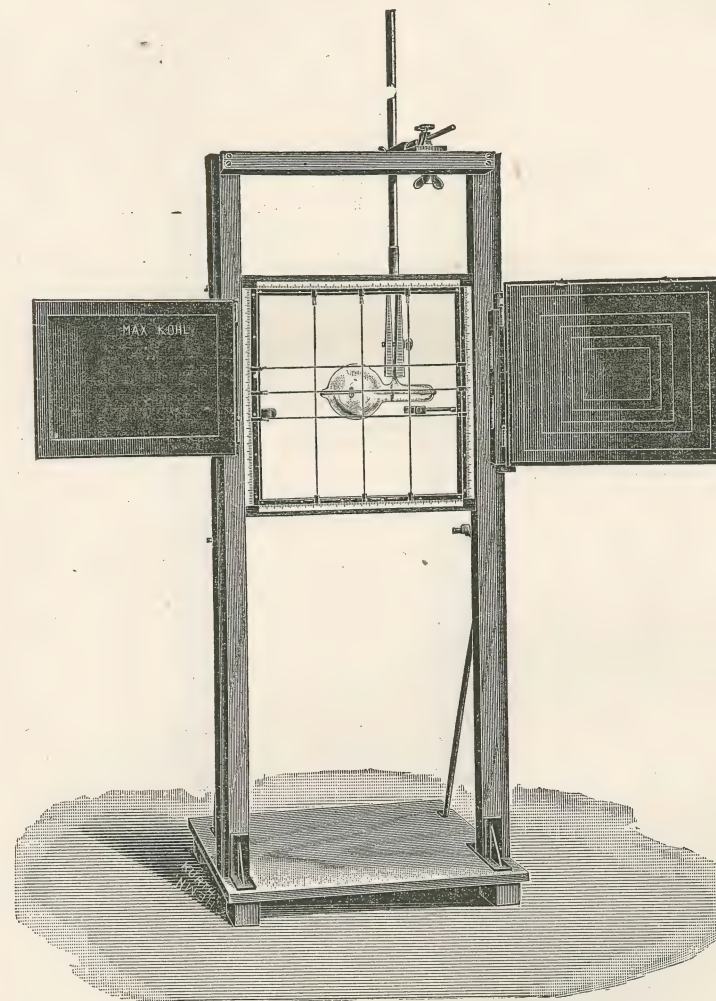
Measuring Stand for X-Ray Examinations Designed by Dr. Hoffmann. The patient sits behind the wires and the operator views from the front. At the left is seen the mounted screen to swing round in front of the patient. On the right is a plate-holder for making a radiograph of the part after the fluoroscopic inspection.
